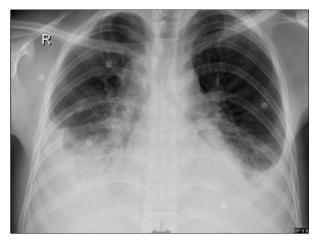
Chest X-ray showing bilateral pleural effusions with nonhomogenous opacity in the right lower zone.
